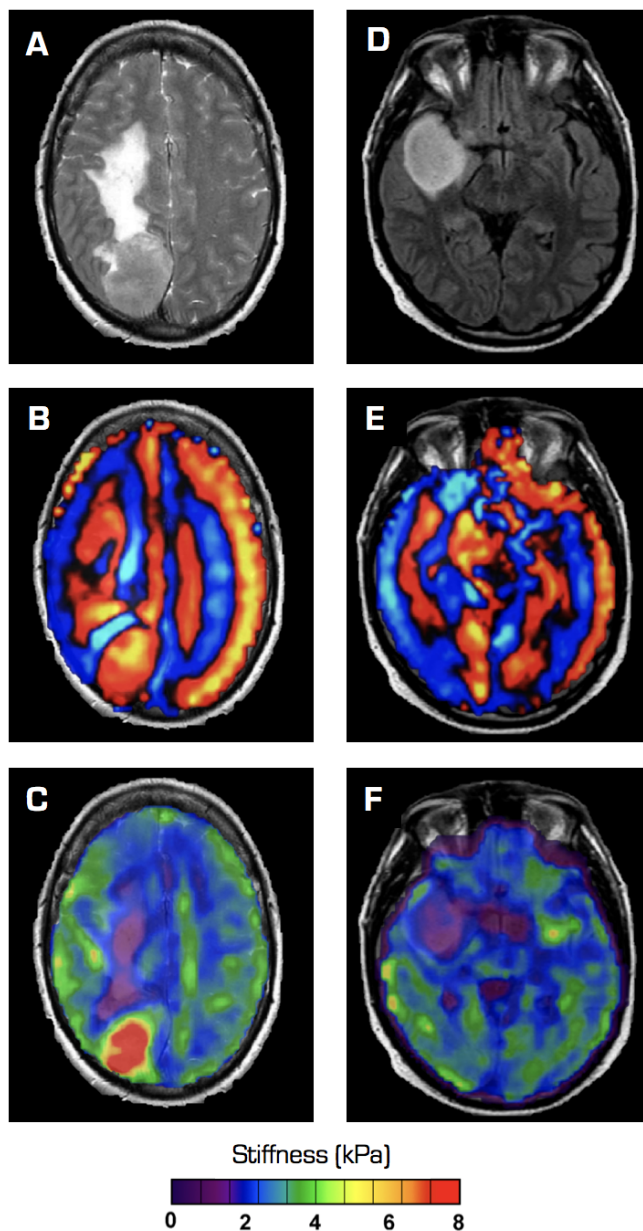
(a-e) MRI and MRE data from 59-year-old female with meningioma: (a) axial  $T_2$ -weighted image demonstrating the tumour and associated oedema; (b) wave image shows longer wavelength throughout the tumour; (c) MRE elastogram shows the tumour to be substantially stiffer, whereas oedema is softer, in relation to unaffected tissue. (d-f) data from 39-year-old male with a glioma (grade IV): (d)  $T_2$ -weighted image showing the tumour mass; (e) wave image displays shorter wavelengths in the tumour; (f) MRE elastogram showing the tumour to be softer compared to unaffected brain tissue. Image adapted from Hiscox et al., 2016 [64] and used with permission.
